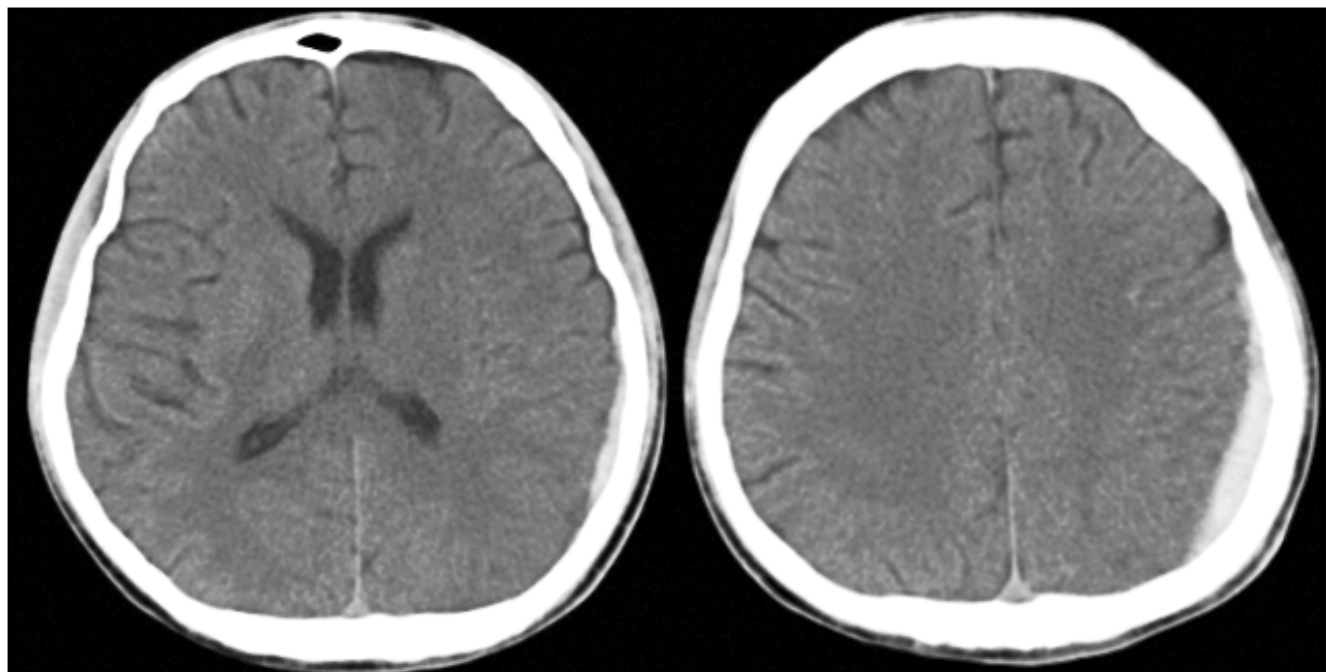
Head CT scan on August 11, 2011. Arcuate high density was seen in the left frontotemporal and parietal surface areas.
